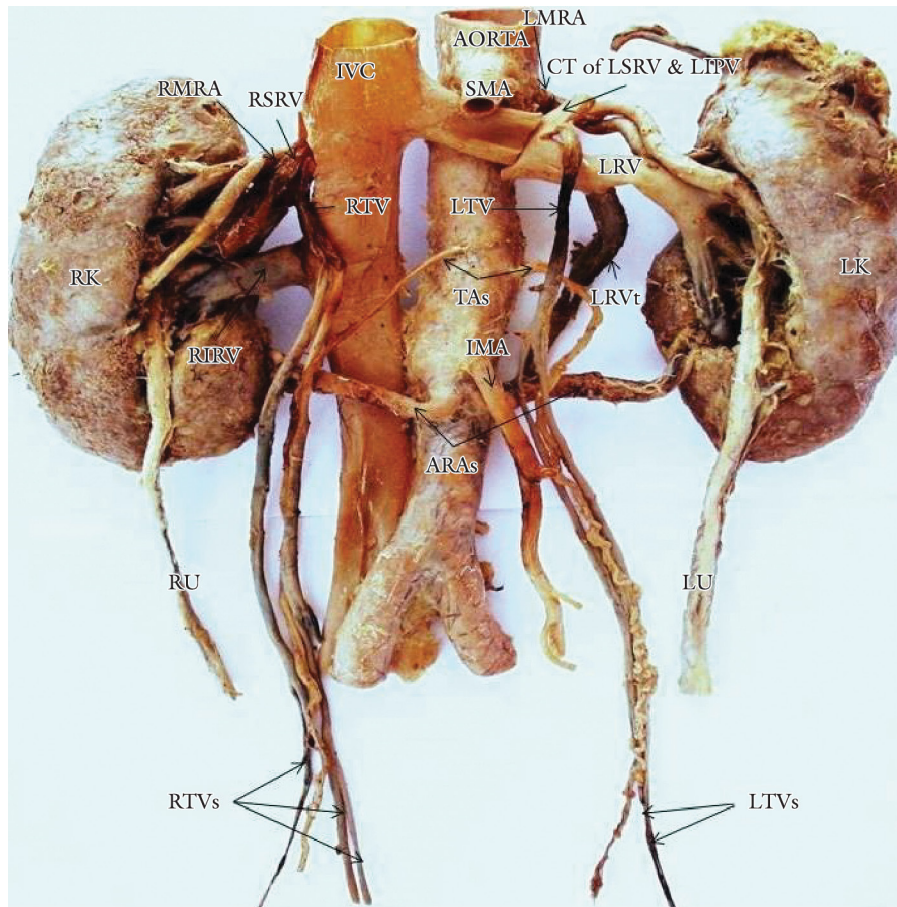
LMRA- left main renal artery; RMRA- right main renal artery; RSRV- right superior renal vein; RIRV- right inferior renal vein; LRV- left renal vein; LRVt- left renal vein tributary; RTV- right testicular vein; LTV- left testicular vein; CT of LSRV & LIPV- common trunk of left suprarenal vein & left inferior phrenic vein; TAS- testicular arteries; IVC- inferior vena cava; SMA- superior mesenteric artery; IMA- inferior mesenteric artery; ARAs- accessory renal arteries; RTVs- tributaries of right testicular vein; LTVs- tributaries of left testicular vein; RU- right ureter; LU- left ureter; RK- right kidney; LK- left kidney.
